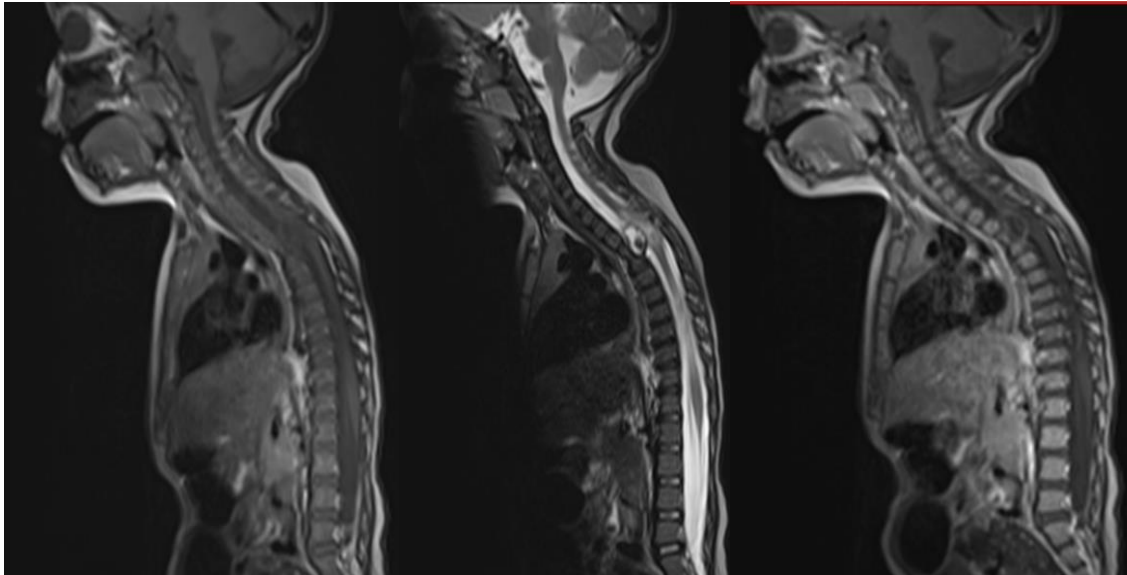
T1, T1 gado, and T2-weighted sagittal section of spinal cord MRI
